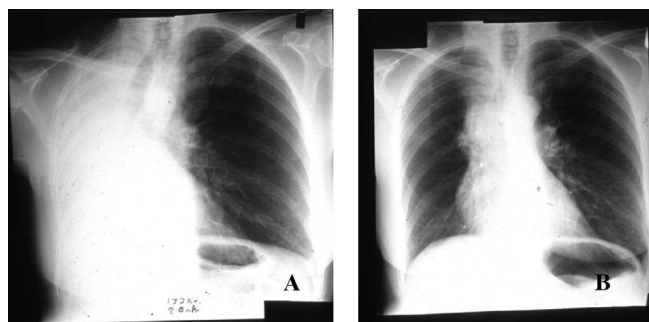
Chest radiograph of a patient presenting with endobronchial malignancy causing obstruction of the right main bronchus and atelectasis of the right lung (A). Chest radiograph of the same patient one day after endobronchial cryosurgery. Destruction of the endobronchial part of the tumor resulted in re-expansion of the lung within 24 hours (B). Necrotic tumor material is usually removed mechanically after each cryosurgery application. Most patients also report that further necrotic material is coughed up at 24 to 48 hours after cryosurgery.
